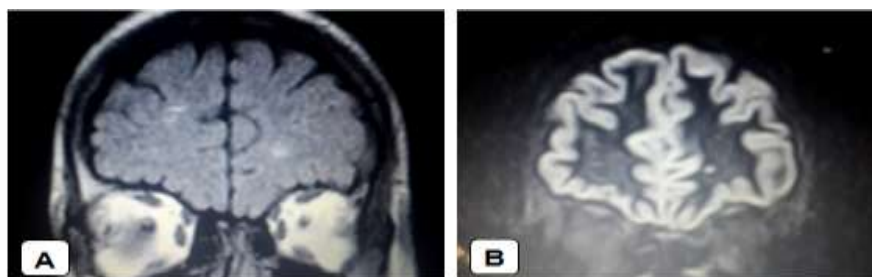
Shows how the DIR (image B) clearly depicts white matter lesion in case of questionable lesion on FLAIR (image A) seen in the Lt. deep inferior frontal area.
